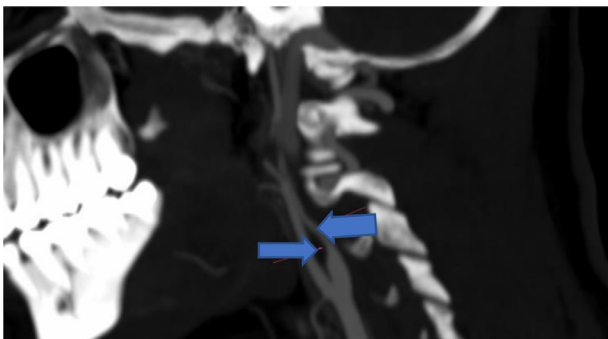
CT angiography Sagittal image showing narrow calibre of ICA.
